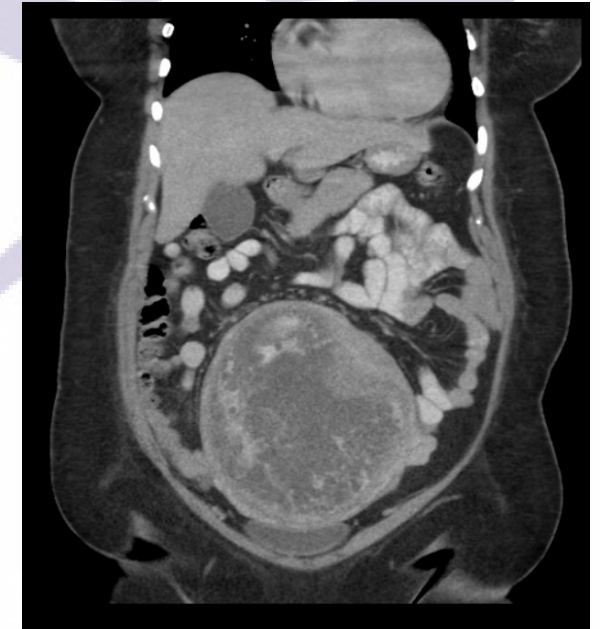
CT abdomen/pelvis demonstrating a complete molar pregnancy 15x12x17 centimeters in size
